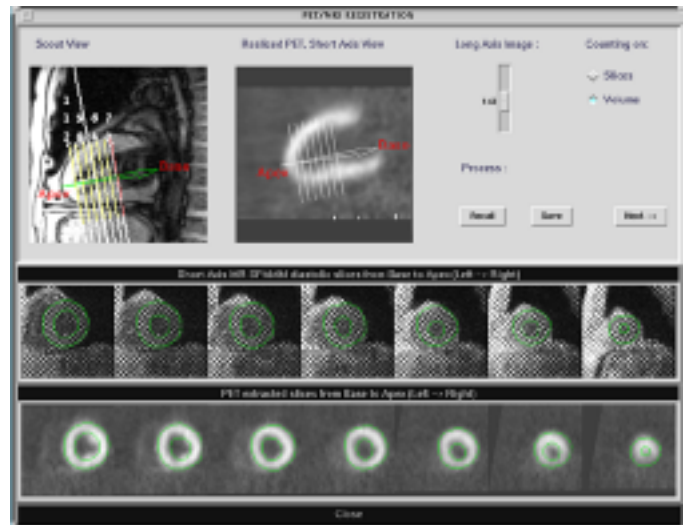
User-friendly interface for partial polar map definition. The PET short-axis slices corresponding to the MRI slices are displayed. The automatically detected LV contours in MRI are mapped on the PET slices.
